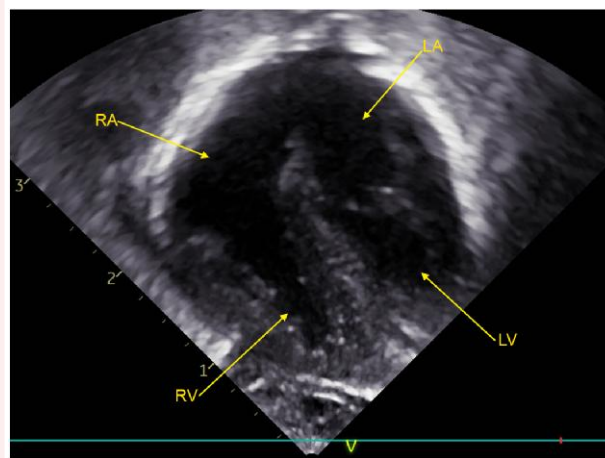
Apical four-chamber view (AV valves open) showing no mass in the right atrium at 5.7 days' age. RA, right atrium; RV, right ventricle; LA, left atrium; and LV, left ventricle.
